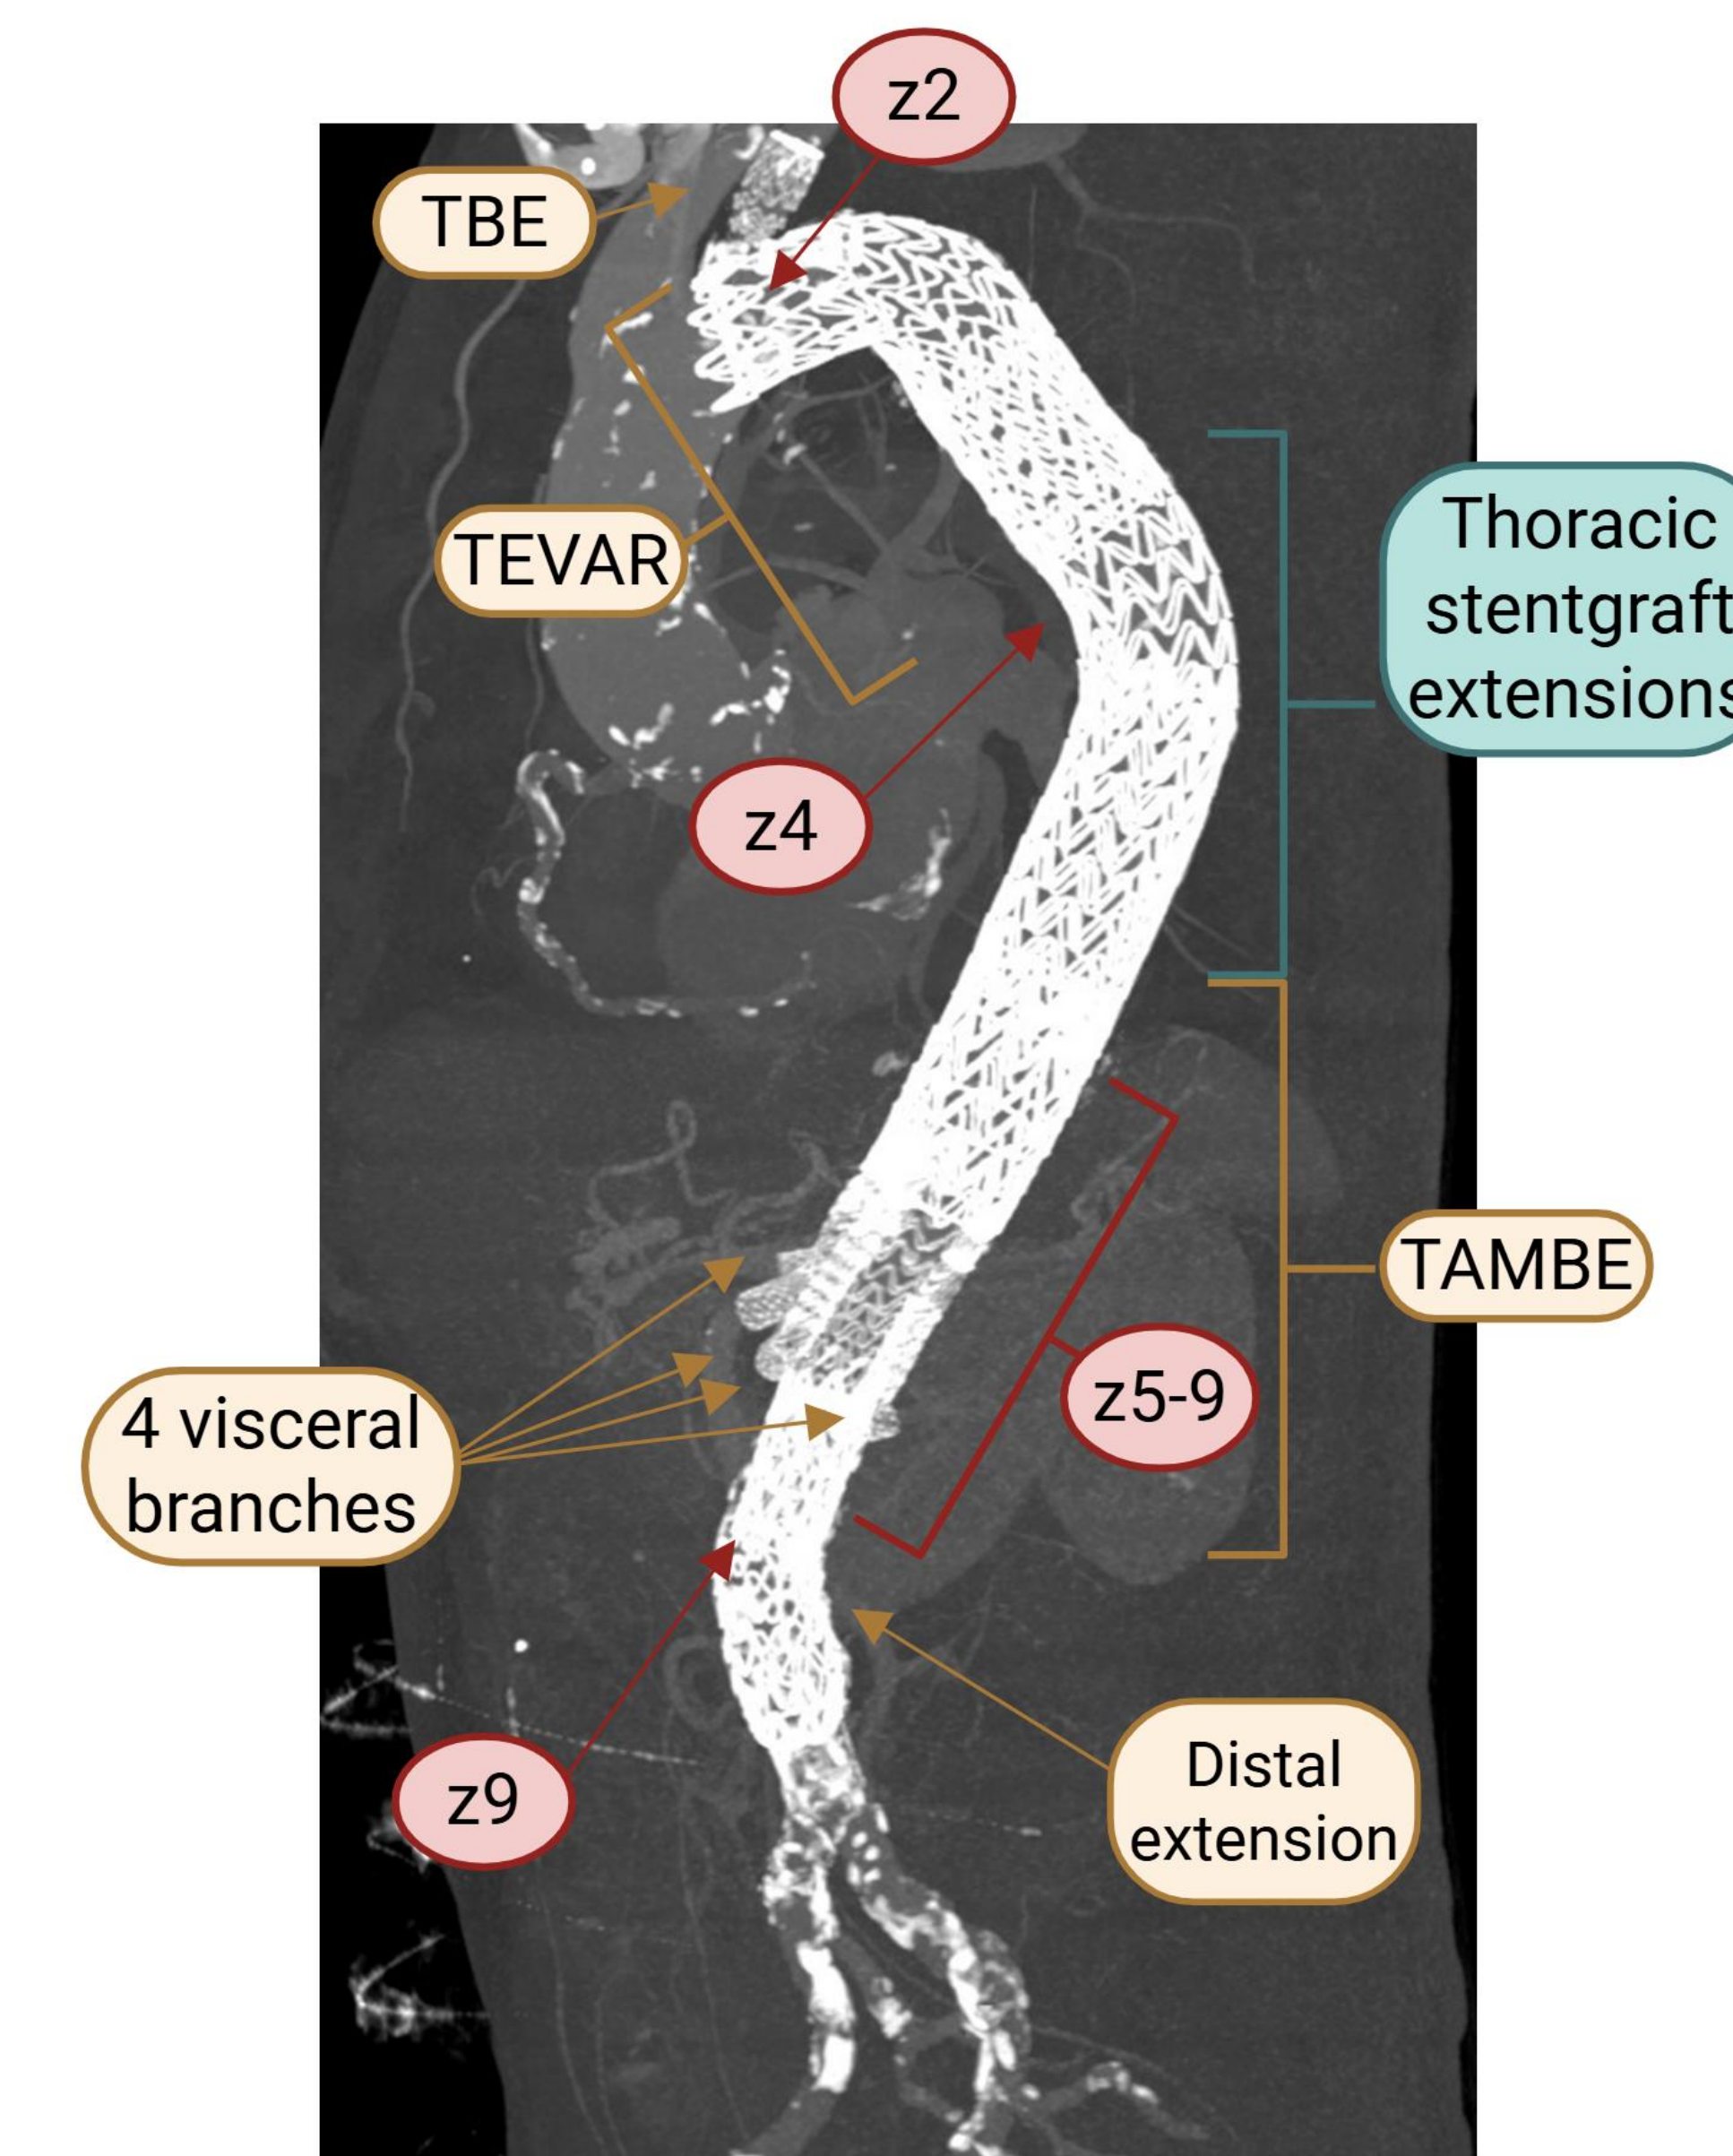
CTA of repair with devices, TEVAR and TAMBE overlap, and aortic zones labeled
